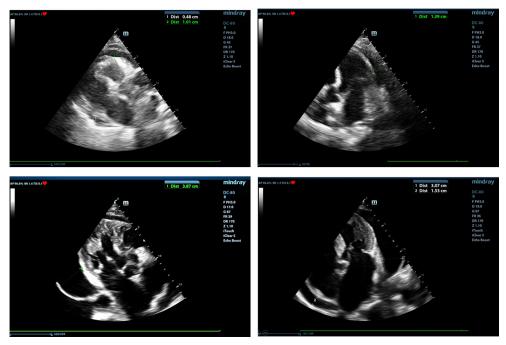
a.4. Upper row: Circumferential pericardial fluid located posterolateral of the left ventricle (0.48 cm) and anterior of the right ventricle (1.01 cm) (2D, parasternal long axis view), and posterior of the left ventricle (1.39 cm) (2D, 4-chambers view).
